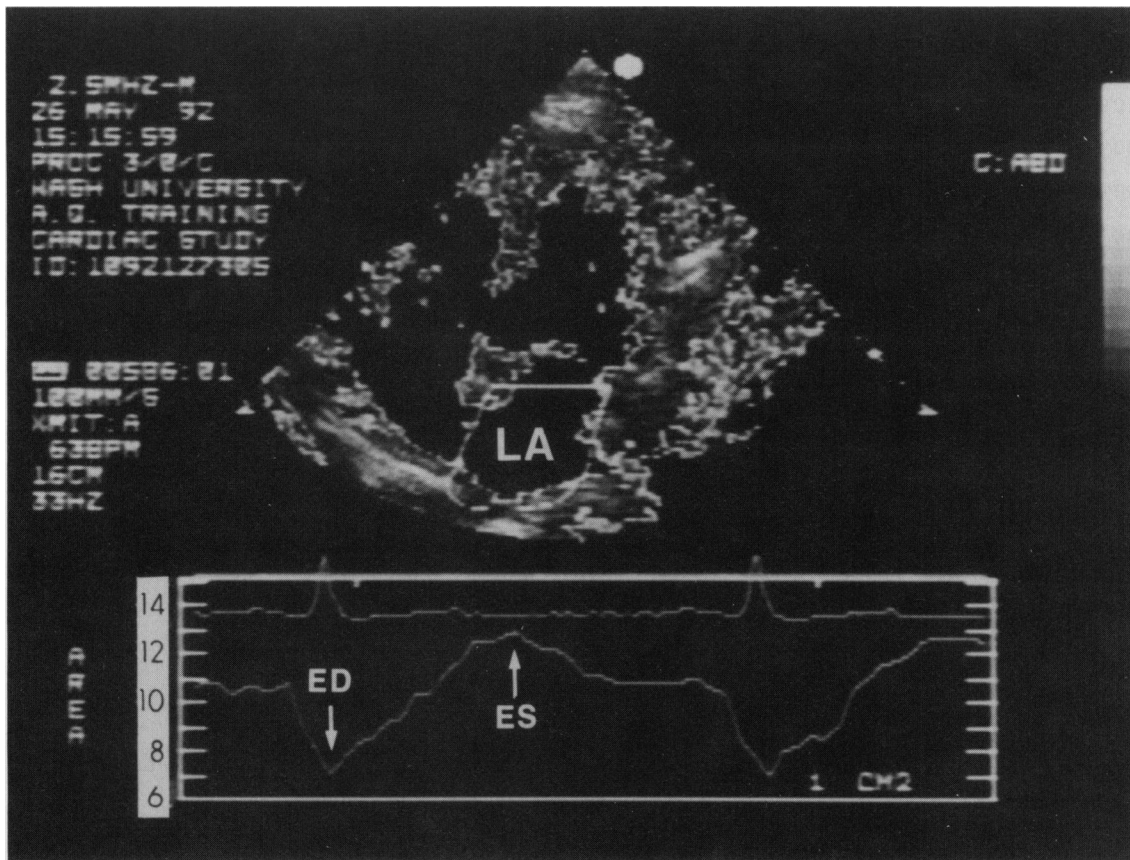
Echocardiographic automatic boundary detection image (top) with the region of interest drawn around the left atrium (LA) and the instantaneous cavity area displayed (bottom). The diastolic emptying index was derived by subtraction of the end-diastolic (ED) left atrial area from the end-systolic (ES) left atrial area divided by the ES area (in percent). The systolic expansion index was derived by subtraction of the end-diastolic left atrial area from the end-systolic left atrial area divided by the ED area (in percent).
